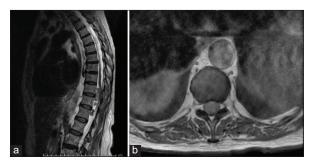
(a) Sagittal T2 MRI of the thoracic spine showing five intradural extramedullary masses at the levels of T10–T12. (b) Axial T1 MRI with contrast showing uniformly enhancing circumscribed lesion at the level of T10, causing severe mass effect on the spinal cord with near-complete flattening.
